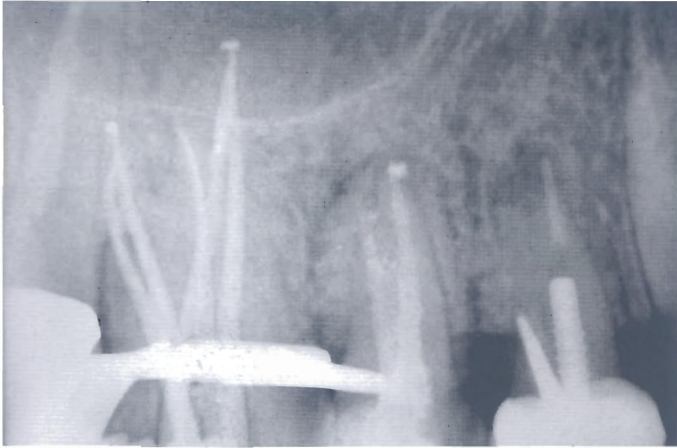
(Continued) H. Postoperative radiograph (G. Cantatore).
